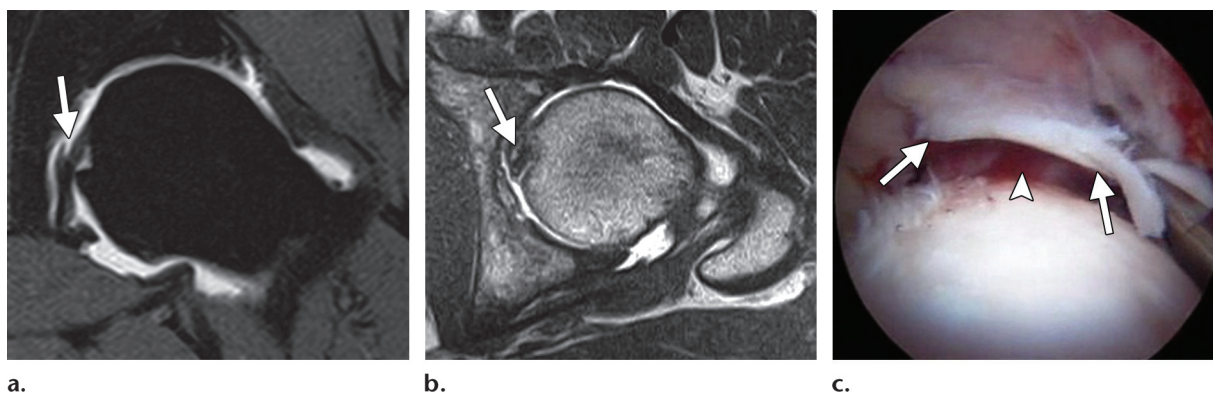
Partial tear of the ligamentum teres. (a, b) Coronal T1-weighted fat-suppressed (a) and axial T1-weighted (b) MR arthrograms obtained in the same patient as Figure 13 show intraarticular extension of contrast material into a partial-thickness tear of the proximal part of the ligamentum teres (arrow). (c) Arthroscopic image shows the partial, superficial flaplike tear (arrows). The rest of the ligamentum teres was intact (arrowhead).
